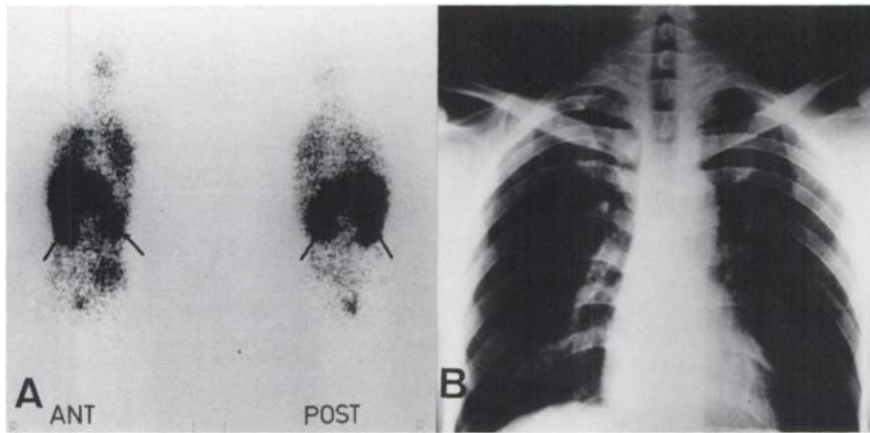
This 29-yr-old male patient had extrapulmonary TB lesions in both kidneys. (A) The whole-body ^{67}Ga scan revealed diffused ^{67}Ga uptake in both lungs and both kidneys (arrows), but the chest x-ray demonstrated no definite abnormality (B).
